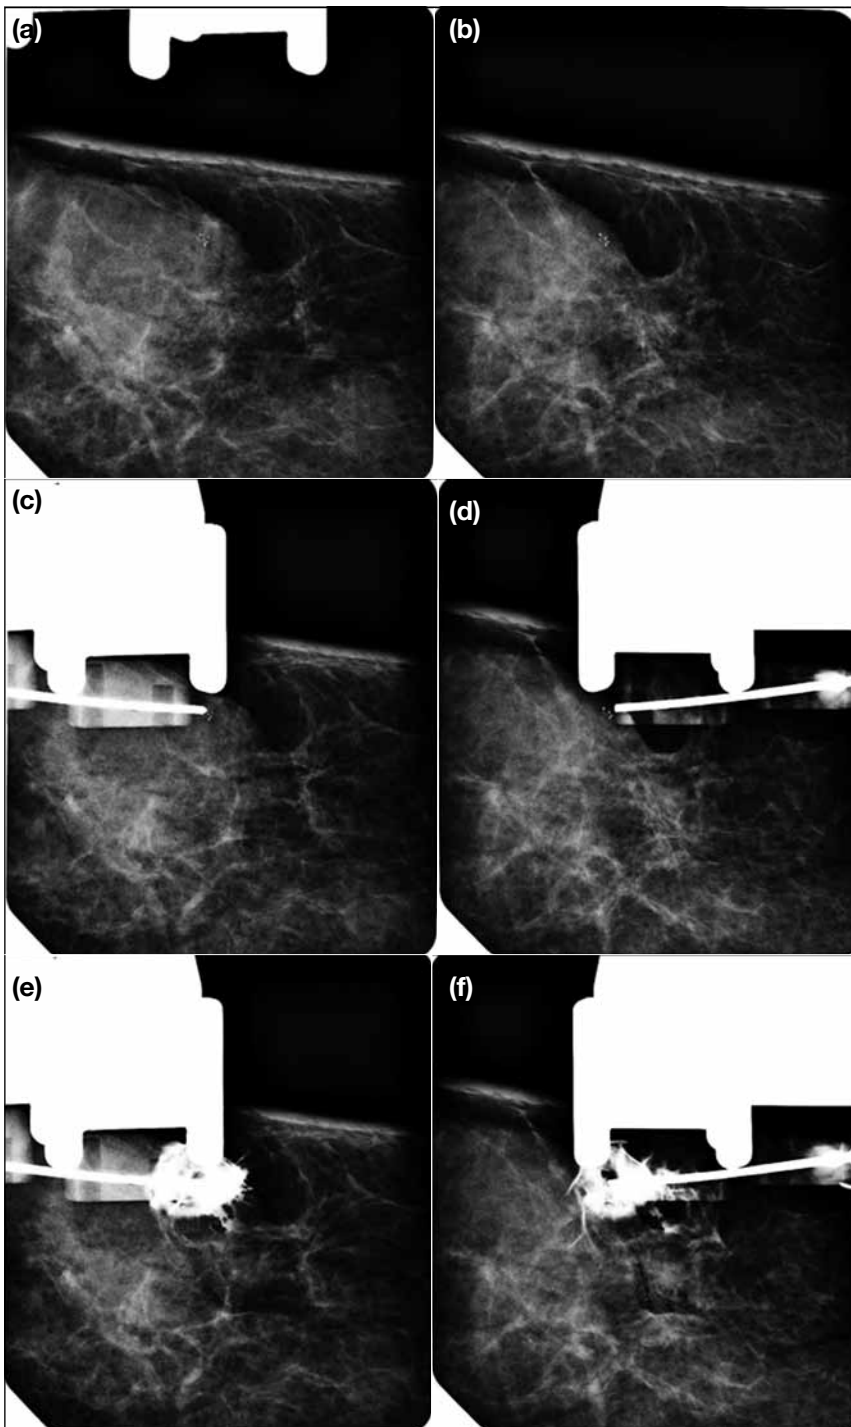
Radiography images of the stereotactic-guided radioguided occult lesion localisation procedure. (a and b) The mammographically detected target lesion is located using a pair of stereo images; (c and d) a 21-gauge spinal needle is inserted into the target lesion with the location confirmed by the pair of stereo images; and (e and f) iodinated contrast is injected to confirm the correct location of the radioisotope placement without inadvertent erroneous intraductal injection.
